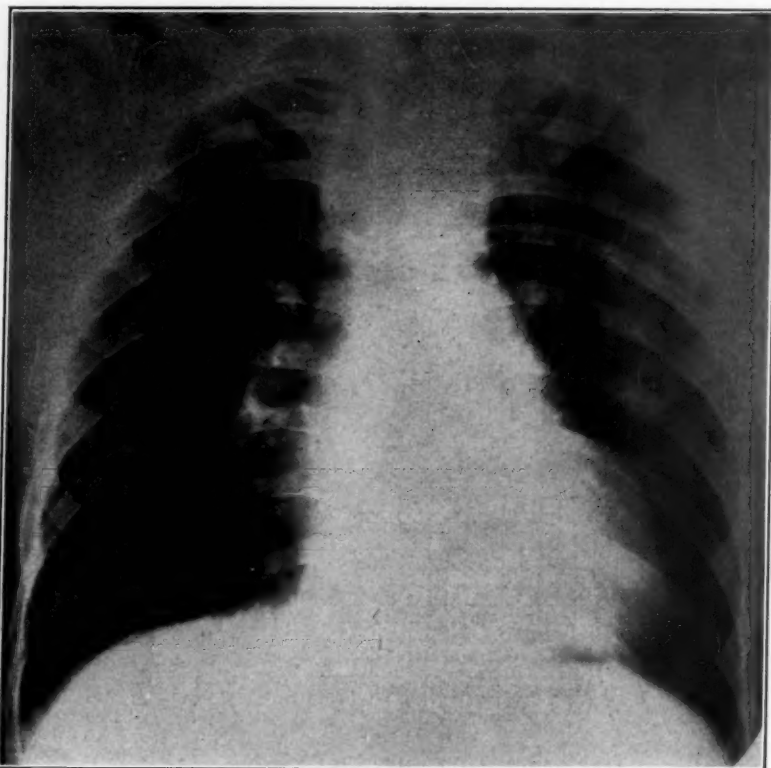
Roentgenologic appearance of coarctation of the aorta: Note the absence of the aortic knob and the erosion of many of the ribs. The left ventricle is hypertrophied.
